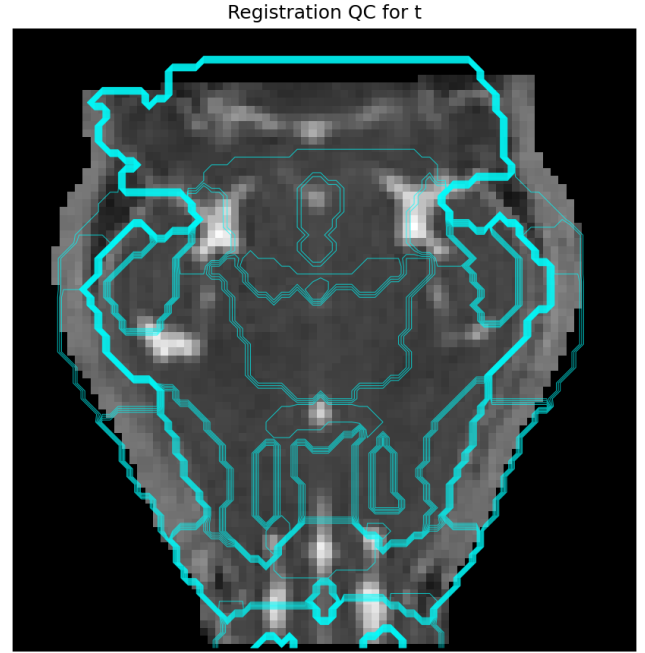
Representative quality control image demonstrating accurate co-registration of the brain atlas (turquoise contours) to a subject's b0-weighted magnetic resonance image (grayscale). This visual check ensured reliable anatomical alignment for subsequent regional brain morphometric analyses.
